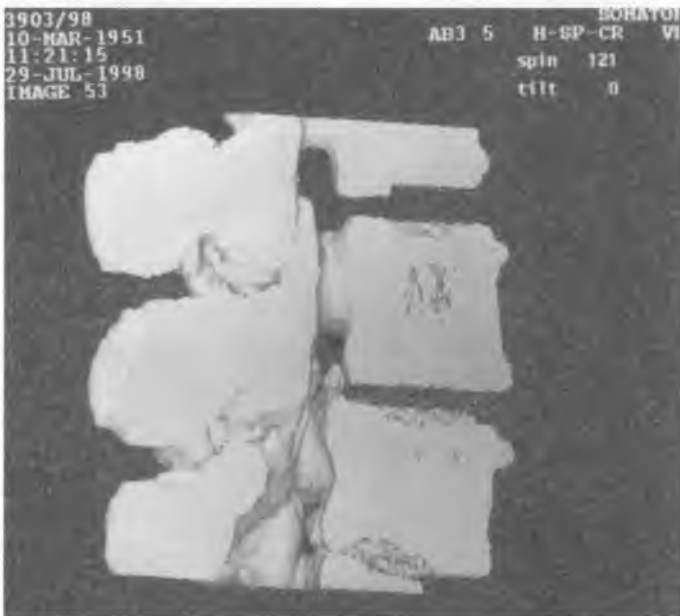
3D CT after cutting off of part of the reconstructed picture in lateral projection from the vertebral lumen shows stenosis of the vertebral canal and intervertebral foramens
